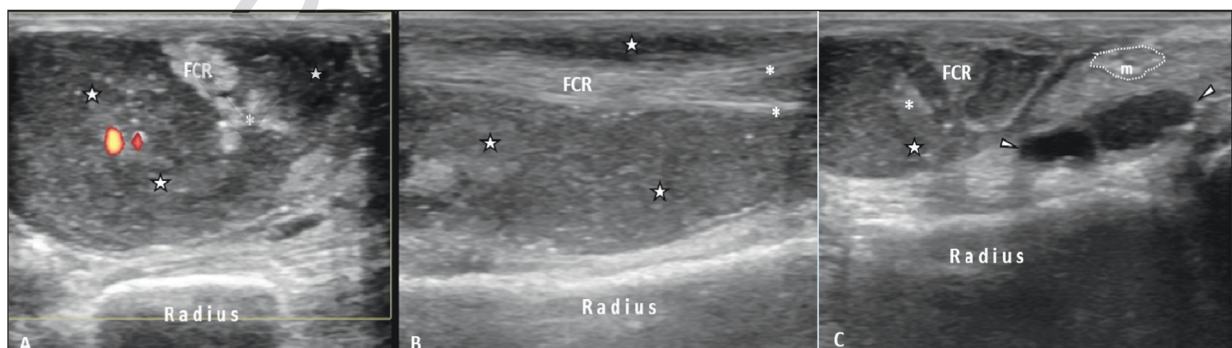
Hypertrophic tenosynovitis of the flexor carpi radialis (FCR). A) Short-axis and B) long-axis ultrasonographic images of the FCR reveal hypoechoic synovial pannus (stars) with doppler activity which causes abnormal distention of the synovial sheath. The FCR is splitted in distal end (asterix) because of synovial proliferation. C) In carpal tunnel level, synovial pannus and fresh fluid (arrow heads) push away the median nerve.
